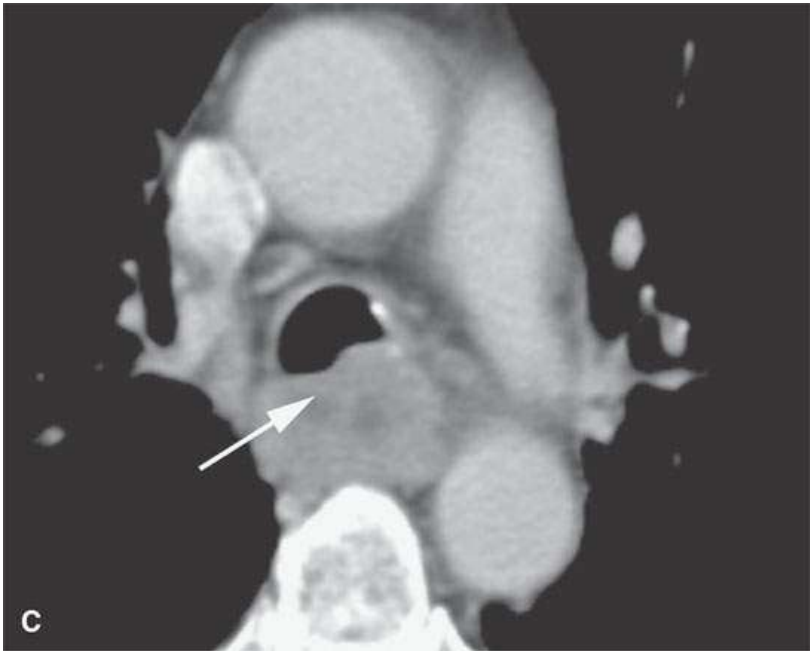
Contrast-enhanced computed tomography studies in two patients with adenoidcystic carcinoma of the larynx (A, B) and trachea (C). A: Tumor grows on the undersurface of the true vocal cord (arrows) and into the soft tissues of the neck (arrowheads). B: Subglottic spread with reactive changes of the adjacent cricoid cartilage. C: Tracheal-origin cancer involving the adjacent esophagus (arrow).
